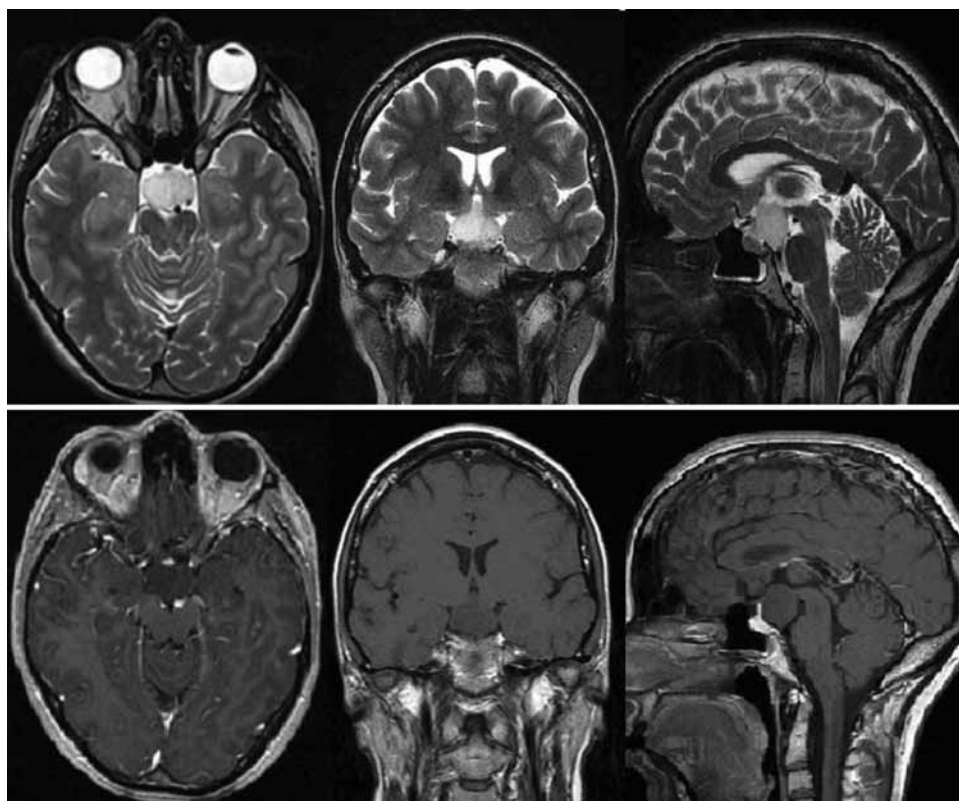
Preoperative axial, coronal, and sagittal MR images showing the hamartoma with an extensive area of attachment to the hypothalamus. The malformation was hyperintense in T2-weighted images (upper) and hypointense without enhancement in T1-weighted images obtained after Gd administration (lower).
